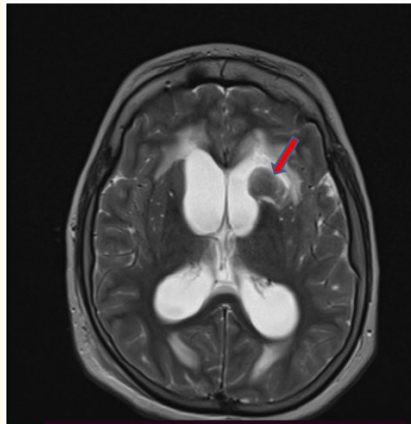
Axial sections of a brain MRI in T2 showing a nodular, supratentorial signal anomaly in the head of the left caudate nucleus, rounded, well limited, with regular contours, in T2 hyposignal and flair isosignal, restrictive to diffusion and low ADC.
